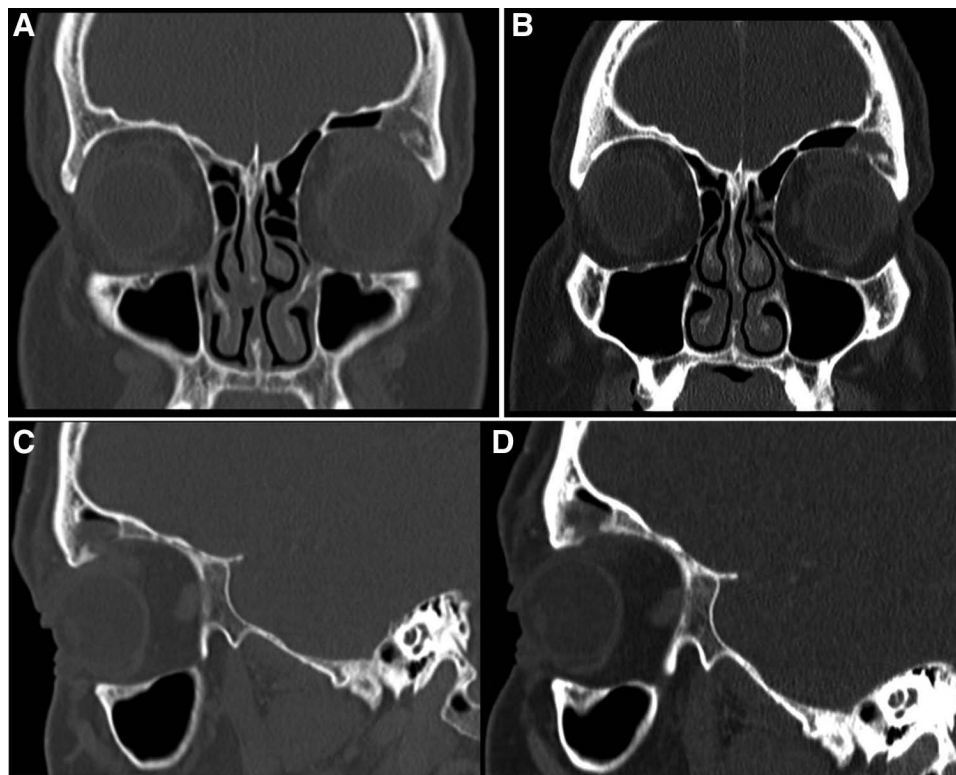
A, Preoperative coronal CT image demonstrating an osteolytic mass lesion in the area of the left lacrimal gland with erosive destruction of the orbital roof. B, Postoperative coronal CT image demonstrating stability of the osteolytic changes, and no recurrence of the lesion. C, Preoperative sagittal CT image demonstrating an osteolytic mass lesion in the area of the left lacrimal gland with erosive destruction of the orbital roof. D, Postoperative sagittal CT image demonstrating stability of the osteolytic changes, and no recurrence of the lesion.
